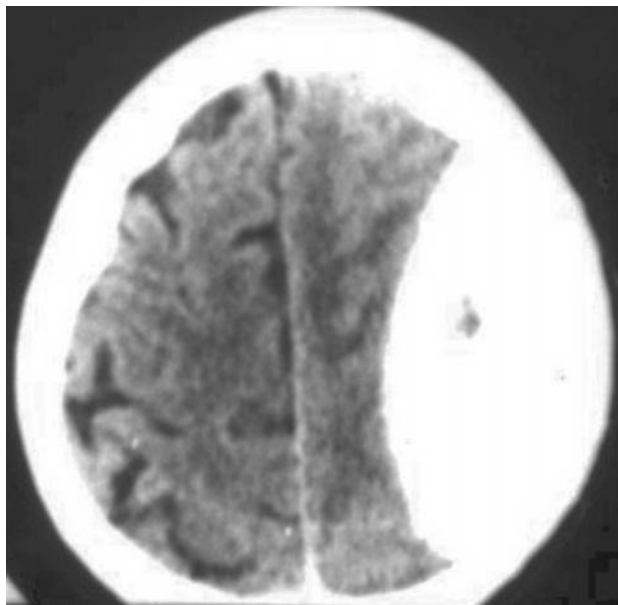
CT axial -left epidural frontoparietal hematoma (hypertintense area with biconvex shape)
